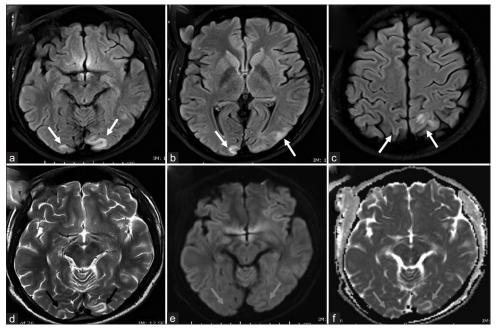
Magnetic resonance imaging of the brain. (a-c) FLAIR images show areas of high signal intensity (white arrows) involving the cortical and subcortical white matter regions of the bilateral occipital and parietal lobes more prominent on the left side. (d) T2 sequence shows corresponding occipital high signal intensity (black arrows). (e, f) Diffusion-weighted imaging and apparent diffusion coefficient sequences show no diffusion restriction (blue arrows) in the occipital lob correspond to the regions of high T2/FLAIR signal intensity which represent vasogenic edema. These findings are typical of PRES syndrome
